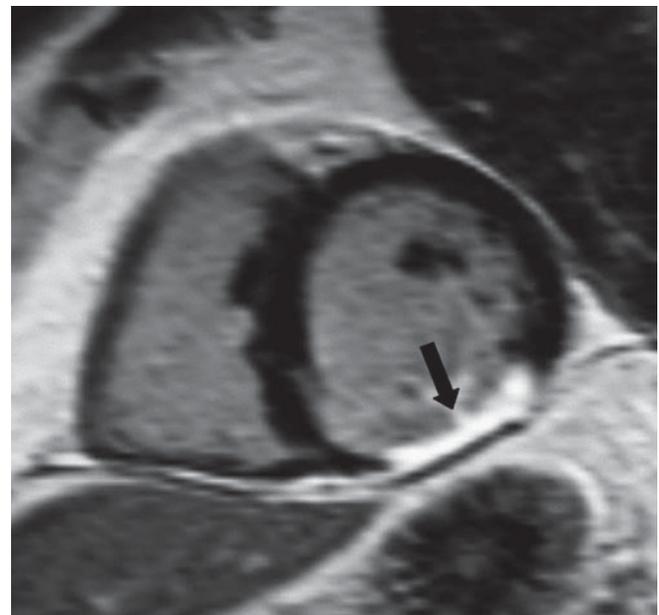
Example of a patient with a trans-mural infarction (scar, arrow) located in the postero-lateral segment of the left ventricle (LV) as identified with contrast-enhanced magnetic resonance imaging
